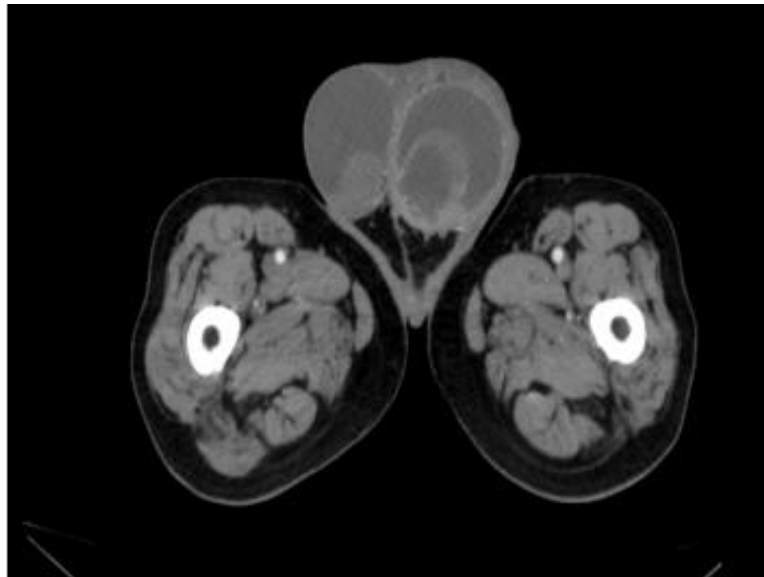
Pelvic CT with evidence of left scrotal abscess and unstructured ipsilateral testis.
